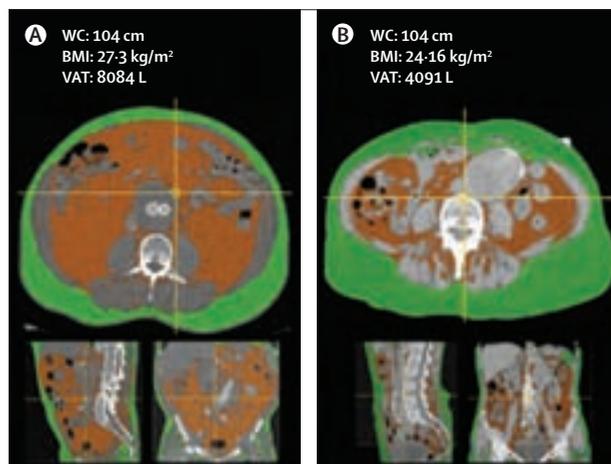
Volumetric measurement of abdominal fat by use of multidetector CT. Patients A and B present with the same waist circumference (WC), but the visceral fat volume is nearly twice as high in patient A as in patient B. BMI=body-mass index. VAT=visceral adipose tissue.
